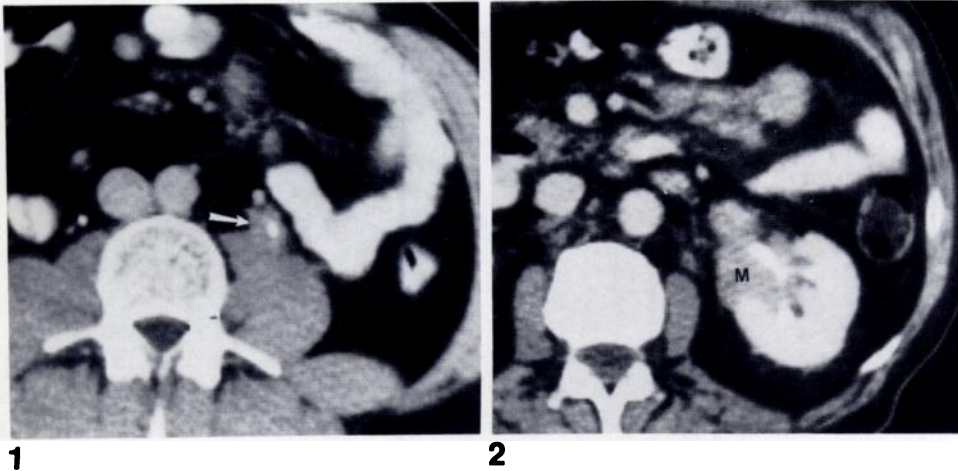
Case 1: poorly differentiated lymphocytic lymphoma. CT scan: thickened periureteral soft tissue (arrow) without contiguous adenopathy.
